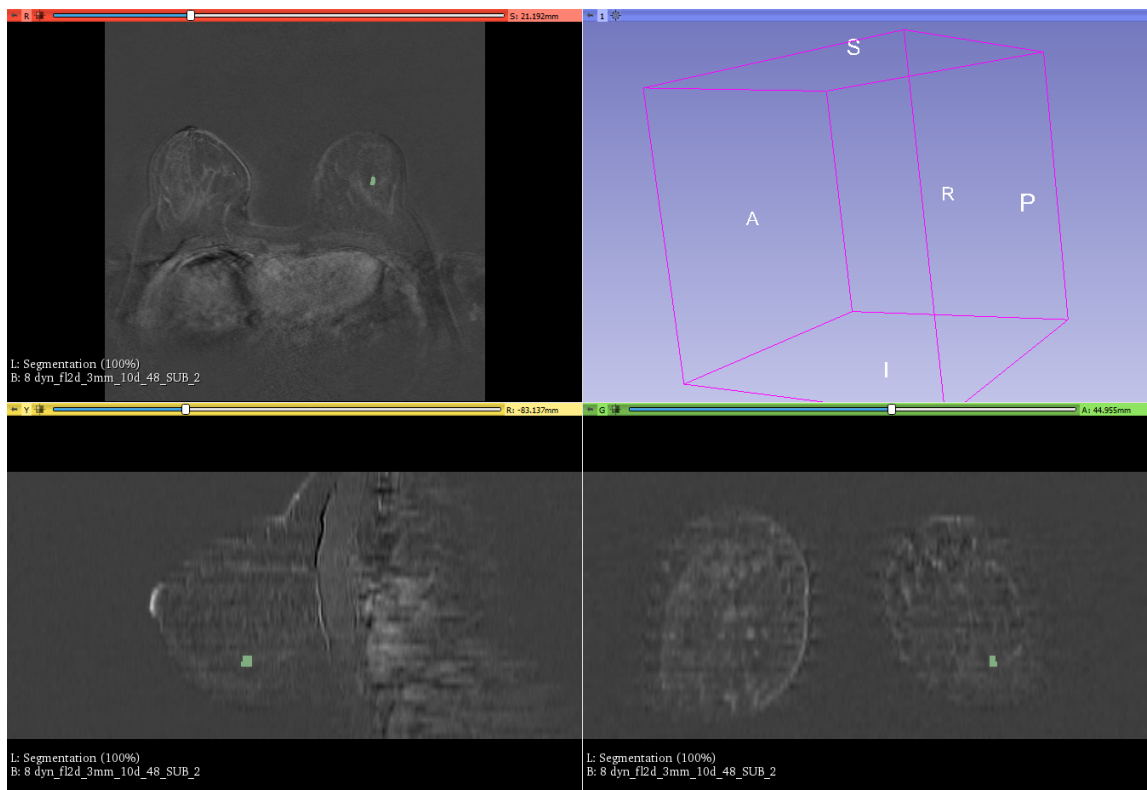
Visualization of an example of annotation done by radiologists using Slicer 3D in a subtraction MRI series. The green area is the annotation of radiologists.
